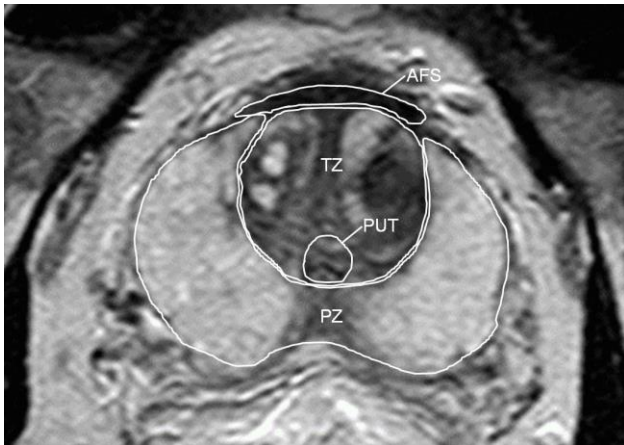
Zonal prostate anatomy on axial T2-weighted MRI image: peripheral zone (PZ) and transitional zone (TZ) are well depicted. Anterior fibromuscular stroma (AFS) and peri-urethral tissue (PUT) are also well detected.
